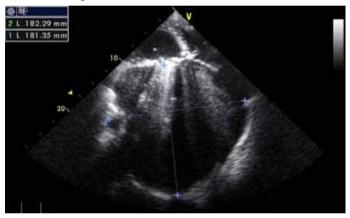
Apical four- chamber echocardiography view demonstrating severe dilatation of left atrium
